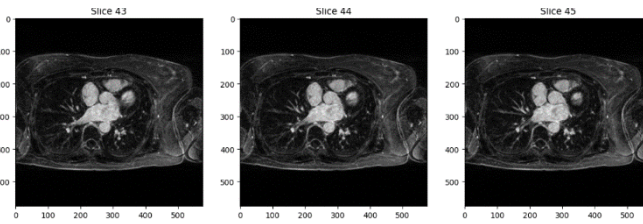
Sample Images from the Cardiac MRI Dataset - This figure displays a selection of MRI slices from the cardiac dataset.
